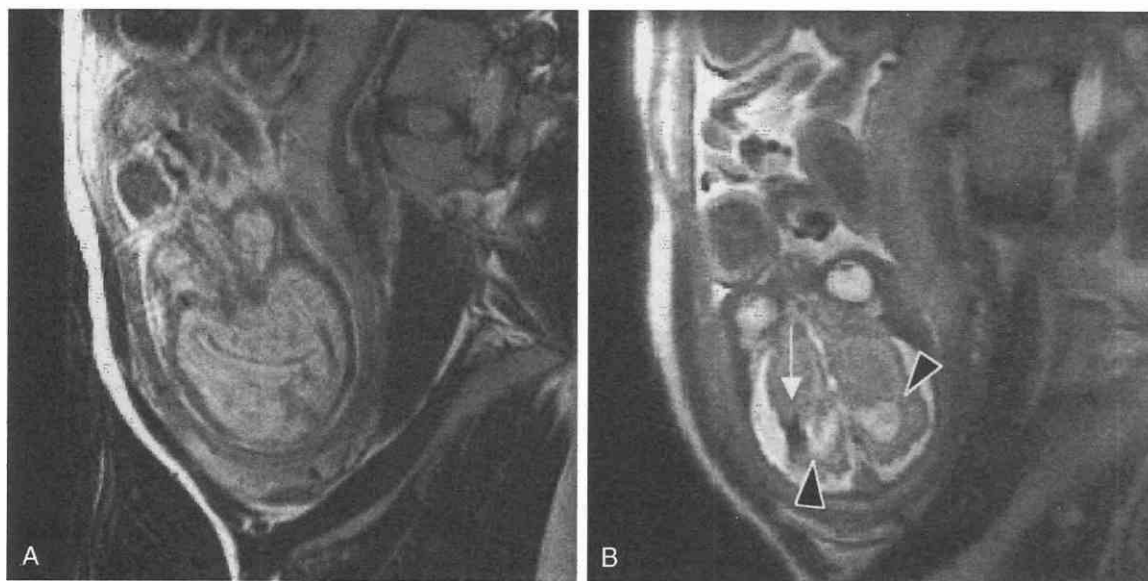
Comparison of conventional T2-weighted, fast spin-echo (FSE) images and single-shot FSE images for delineation of fetal anatomy. A, T2-weighted FSE image (TR = 2000 msec, TE_{eff} = 99 msec; two signal acquisitions) shows marked motion artifact related to fetal motion and maternal respiratory motion. Fetal anatomy is blurred and indistinct. B, Single-shot FSE image (TR = 16,000 msec, TE_{eff} = 96 msec, 0.5 half-Fourier acquisition) shows more discrete fetal anatomy with depiction of the cerebral lateral ventricles (arrowheads) and low-signal-intensity cerebral infarction (white arrow) in this patient with TORCH syndrome (toxoplasmosis, rubella, cytomegalovirus, herpes). TE_{eff}, effective echo time.
